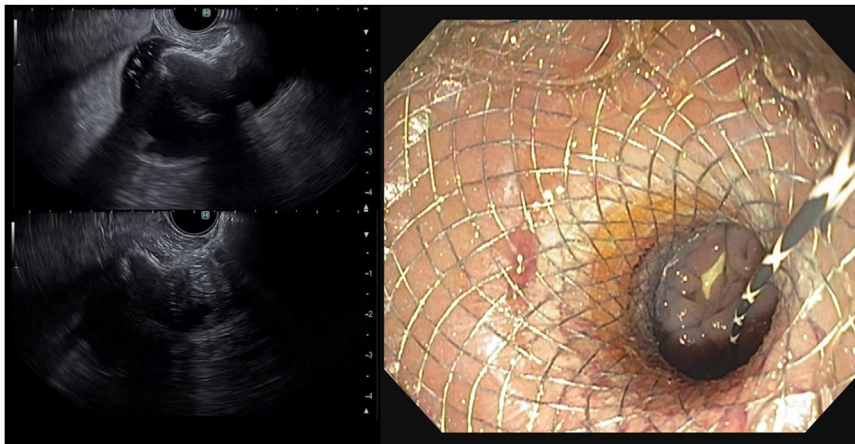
Deployment of the lumen-apposing metal stent in the jejunum under endosonographic guidance.
